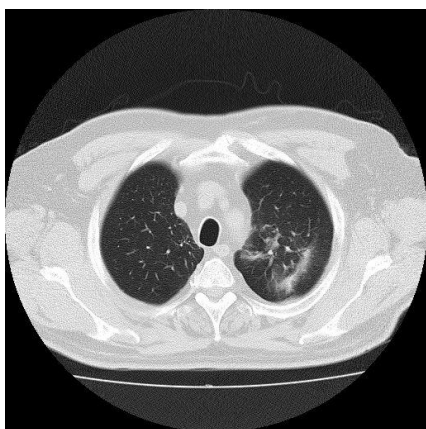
Computed tomography scan of thorax (05/2020): enlargement of dimensions of infiltrative and banded atelectatic lesions in left lung apex.
